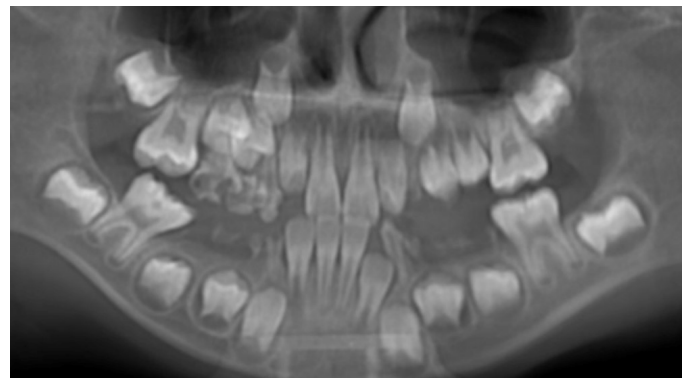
CBCT image showing the root stumps (#63, 65, 74, 73, 83, 84 and 85) without evident apical inflammation, periapical periodontitis (#55 and 54), caries (#53, 16, 26, 36 and 46) and premature eruption (#24 and 25).
